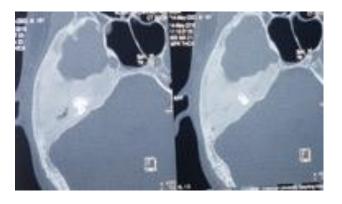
HRCT temporal bone showing ground glass appearance.
